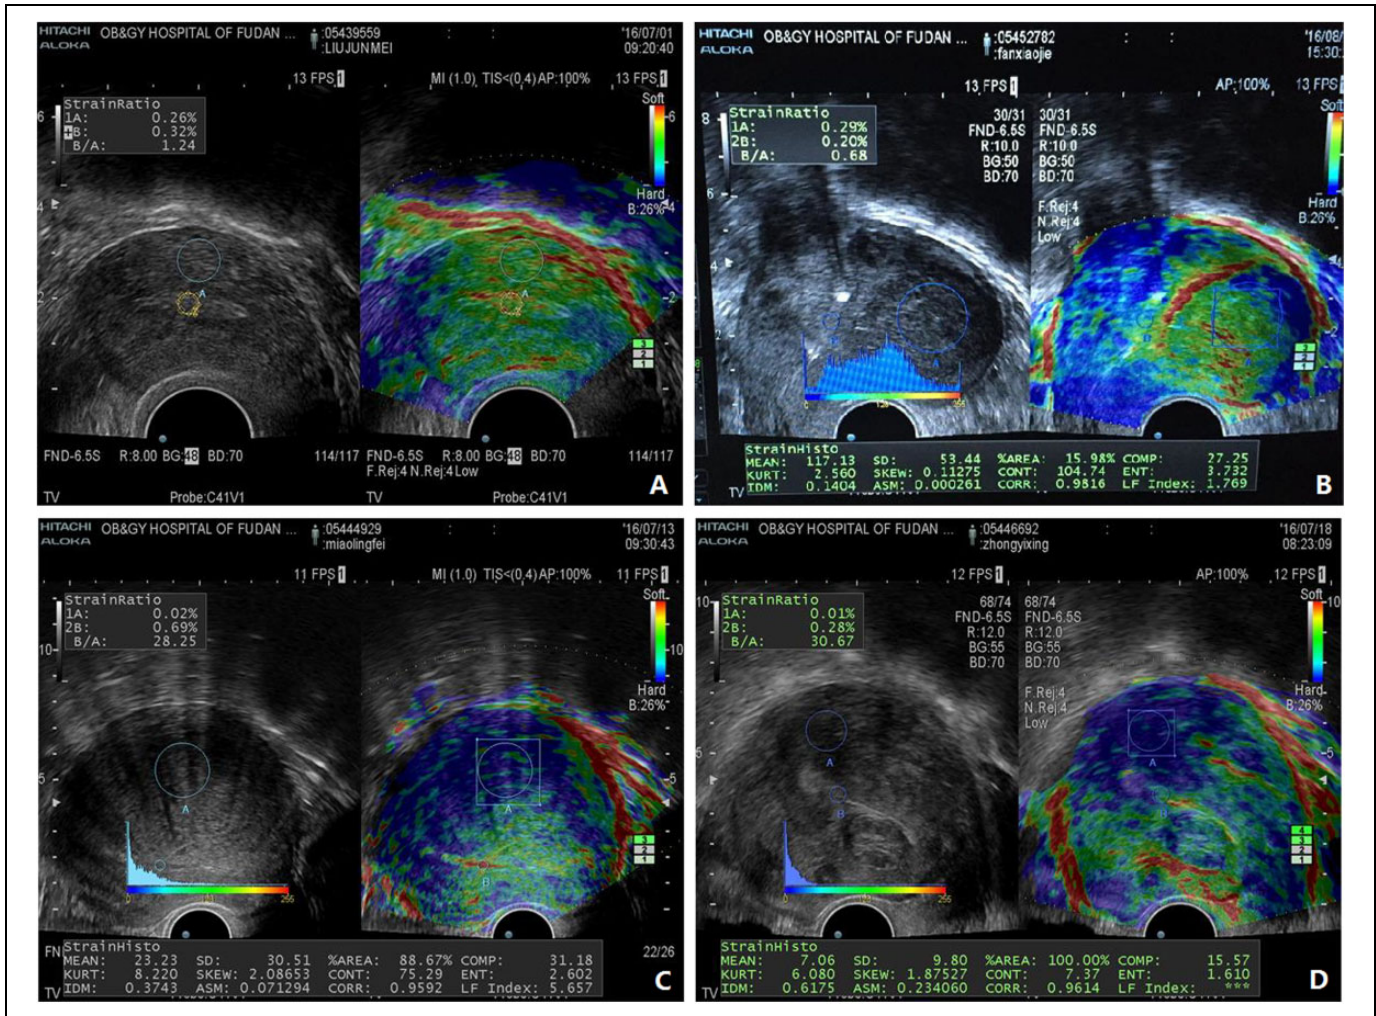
Representative transvaginal elastosonographic photos of different tissues: (A) normal myometrium shows the most green and less yellow color represents mild stiffness of the tissue; (B) uterine fibroid shows the most green and less blue color represents medium stiffness of the tissue, and there is also a typical red color pseudocapsule that circling around the fibroid; (C) diffuse adenomyotic tissue shows the broad area of blue color representing the even stiffer tissue; and (D) focal adenomyosis with co-occurrence of uterine fibroid. Focal adenomyotic tissue (the upper left area) shows the local area of blue color representing the even stiffer tissue. The uterine fibroid (the middle lower area) shows a typical red-colored pseudocapsule that circling around the fibroid. Typical serosal surface of uterus shown in red color could be seen in every uterus.
